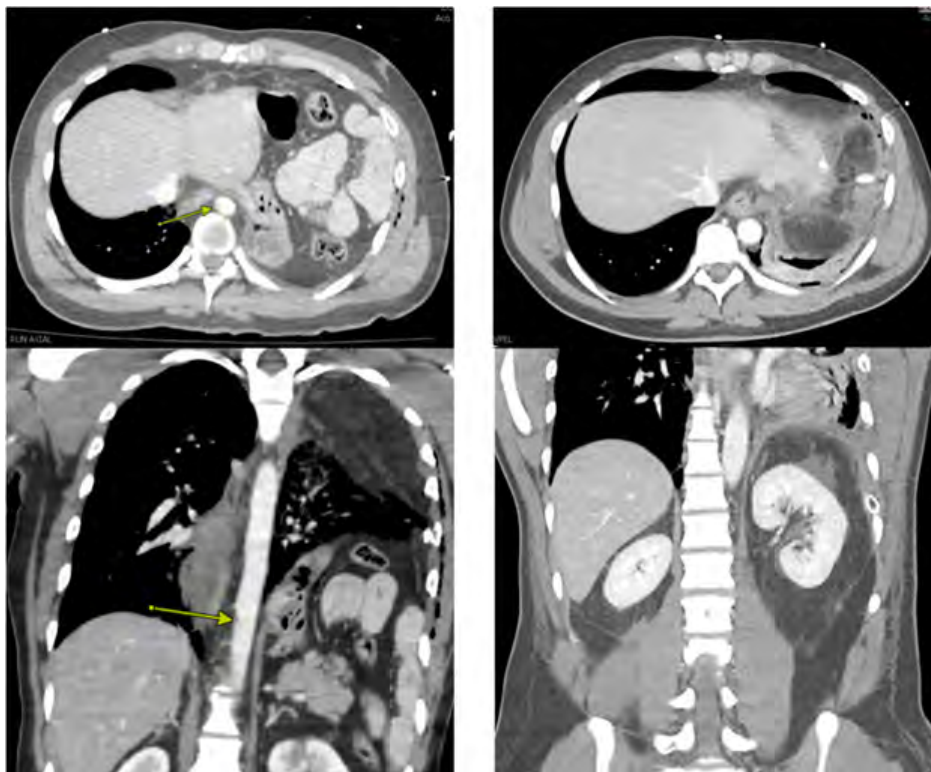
CT scan demonstrating MAI (left) on presentation with interval scan (right) demonstrating resolution.
